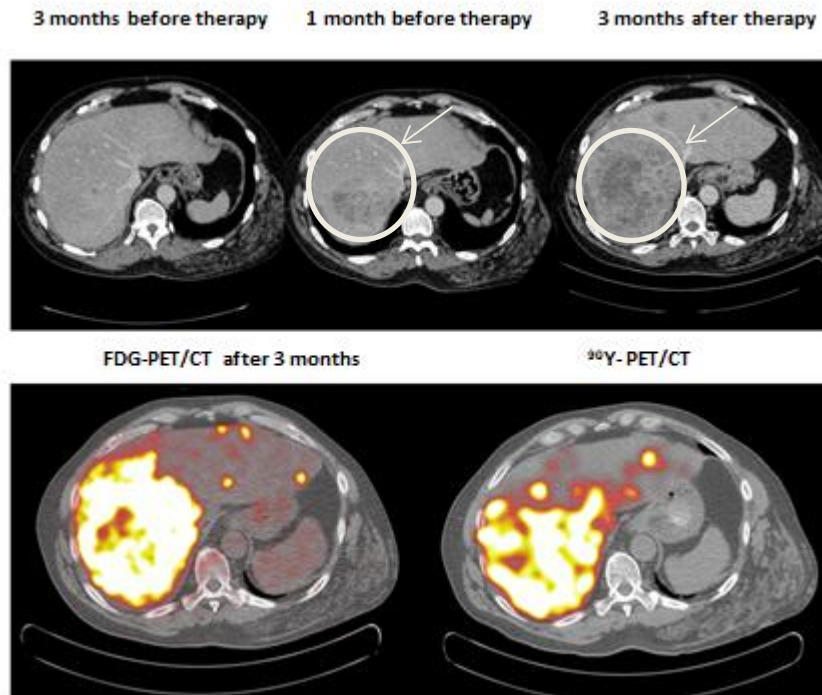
Example of a very poor local response to radioembolisation. This patient has extensive liver metastases, which keep growing despite chemotherapy. An adequate microsphere accumulation in and around the liver lesions is observed after radioembolisation at the ^{90}Y -PET/CT scan (^{90}Y -dose 1.7 GBq, total liver volume 3200ml, estimated tumor volume 980ml). However, new hepatic lesions are observed at the FDG PET/CT scan after three months [6].
